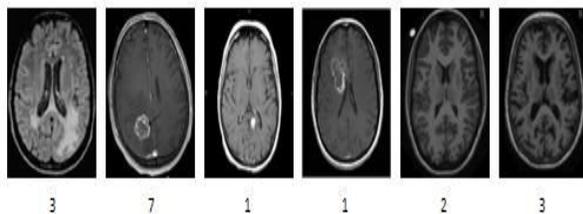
Incorrectly Detected MRI Images
